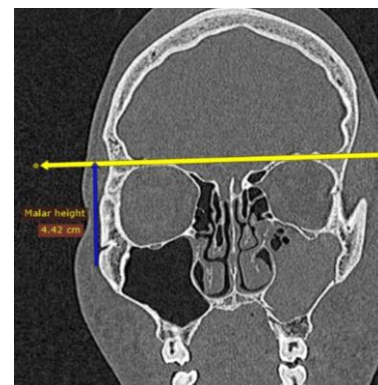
Preoperative radiographic malar height on the normal side.
